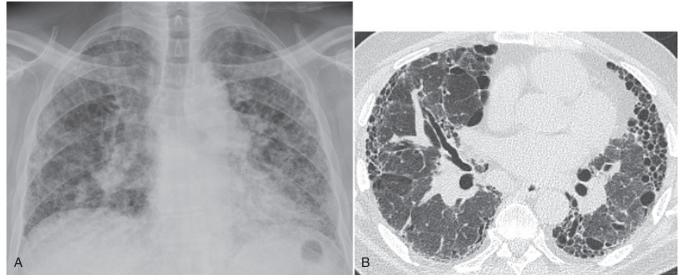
Posteroanterior view (A) of the chest in a patient with shortness of breath. The chest x-ray shows interstitial lung disease. The lung volumes are small. Coarse linear and cystic lucencies represent pulmonary fibrosis. These findings are better visualized on the chest computed tomography image (B), where there is bronchiectasis, architectural distortion, and honeycombing. The patient has interstitial pulmonary fibrosis, the most common type of pulmonary fibrosis.
